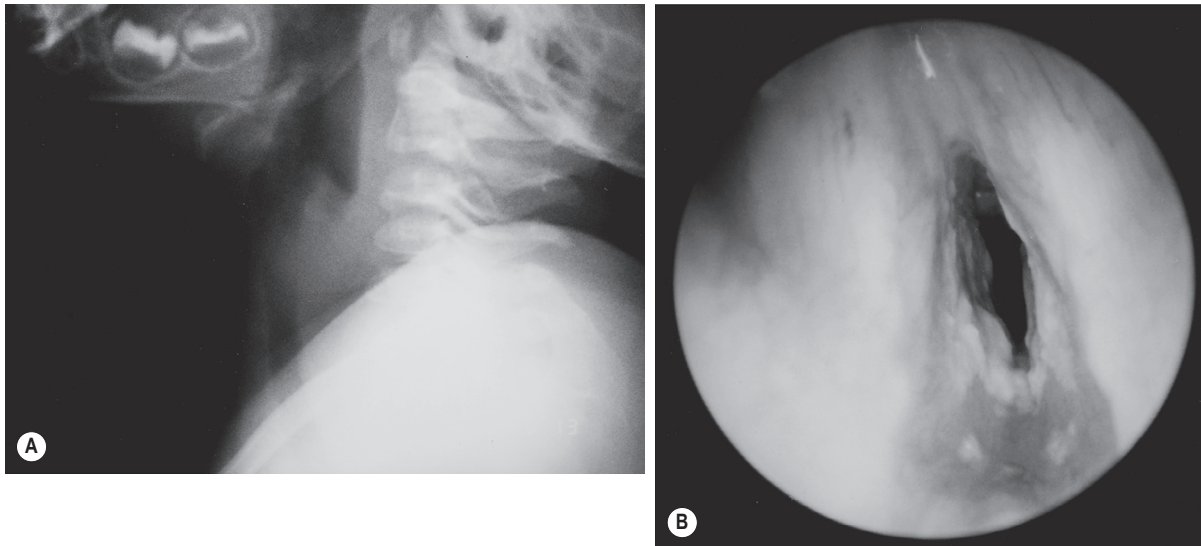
(A) Lateral neck radiograph of a 22-month-old boy with bacterial tracheitis caused by *Staphylococcus aureus* shows subglottic haziness (similar to croup). (B) Endoscopic view of the trachea shows mucosal denudation, intraluminal debris, and purulent laryngotracheal secretions. (Courtesy of Richard H. Schwartz, MD, Vienna, VA.)
